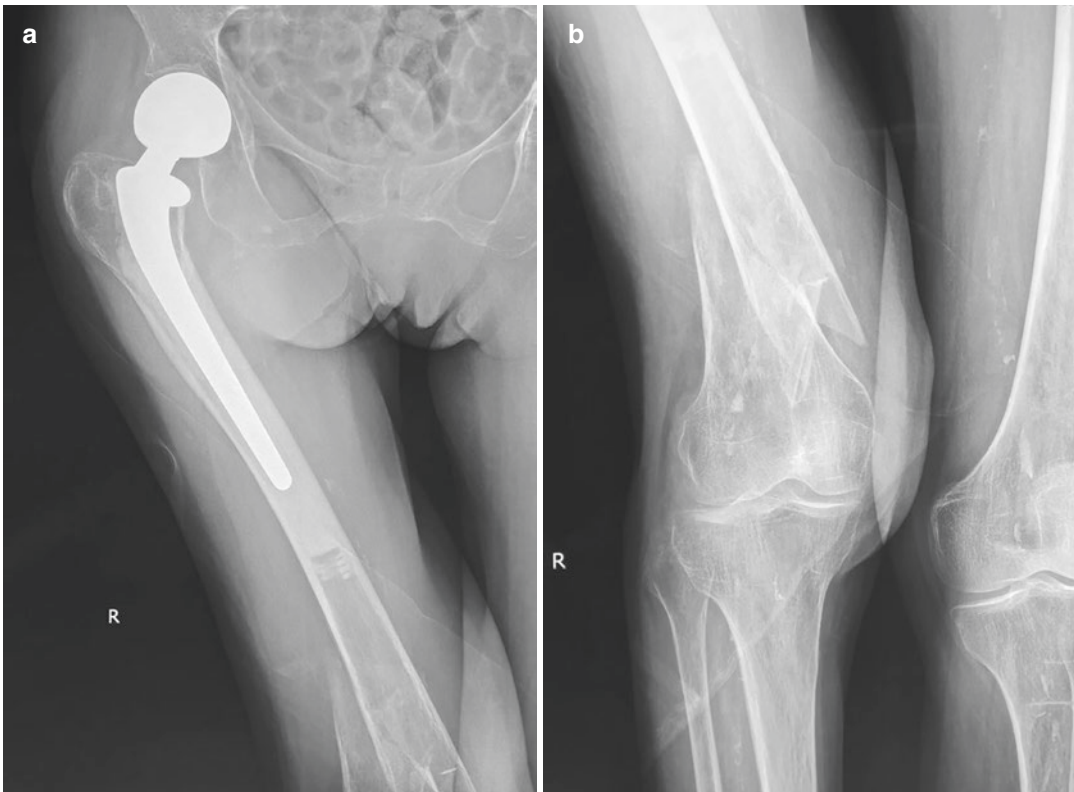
Radiograph of a periprosthetic femoral fracture type C after revision total hip arthroplasty. (a) Radiograph on the proximal site. (b) Radiograph on the distal site
